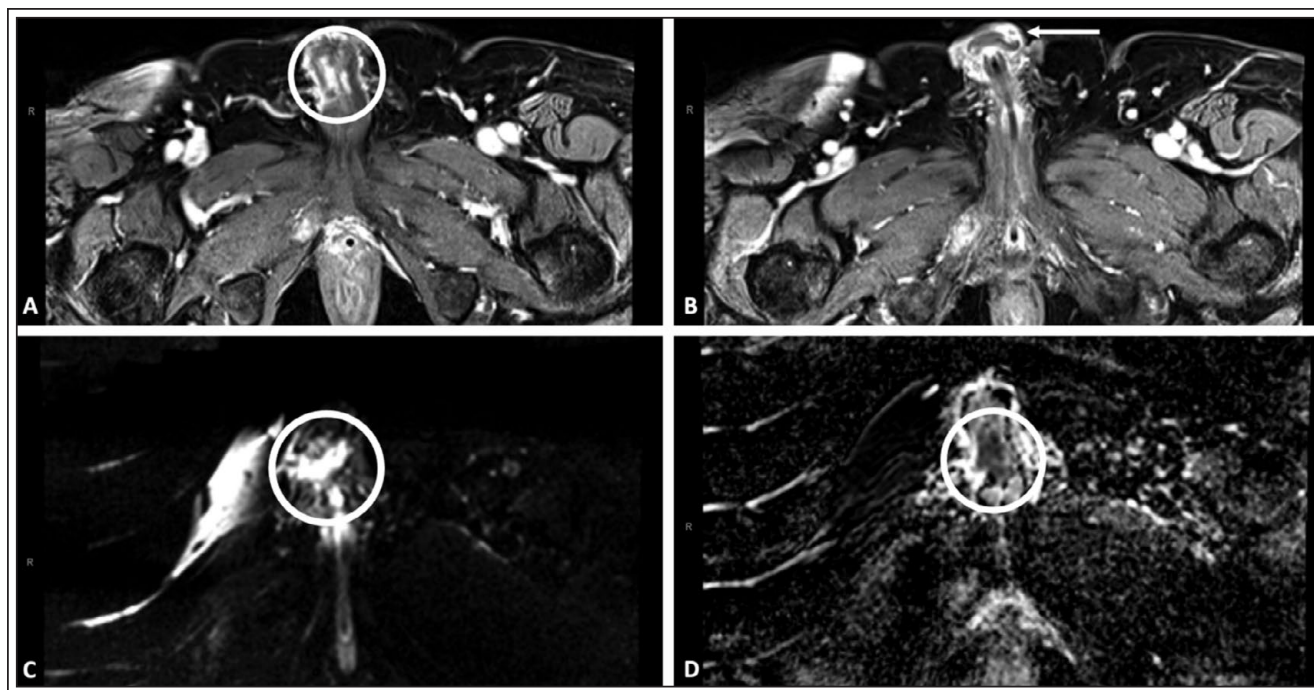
(A) Nodular irregular enhancement in the mid-penile shaft involving the corpus cavernosum and spongiosum on axial post-contrast T1-weighted fat suppressed image. (B) 1.1 mm peripherally enhancing subdermal nodule in the left base dorsal penile shaft on post-contrast T1-weighted fat suppressed image. The irregular corporal lesions show restricted diffusion, as evidenced by hyperintensity on diffusion-weighted imaging (DWI) with corresponding deficit on ADC (C, D).
